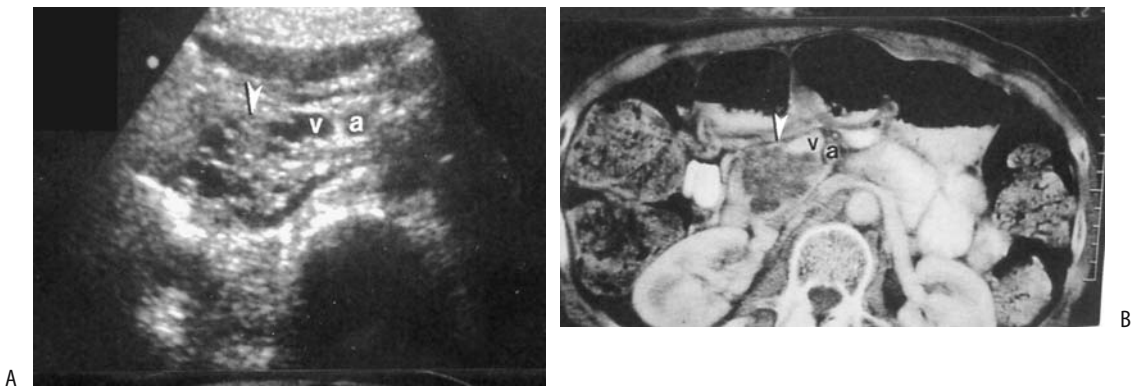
Microcystic adenoma. Transverse US (A) and CT (B) identify a tumor in the pancreatic head (arrowhead) (a, superior mesenteric artery; v, vein). (Source: From Yeh HC, Stancato-Pasik A, Shapiro RS. Microcystic features at US: a nonspecific sign for microcystic adenomas of the pancreas. *RadioGraphics* 2001;21:1455–1461, with permission from the Radiological Society of North America.)
